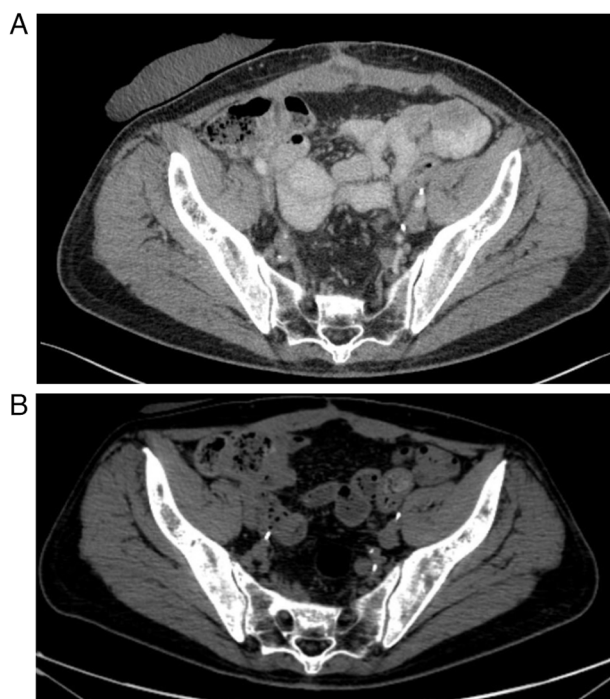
(A) First follow-up CT scan. Progression of the disease: Foci of sclerotic remodeling found in the pelvis. (B) Follow-up computed tomography performed in December 2023-further progression of the disease.
